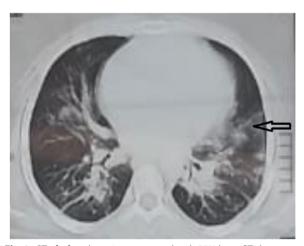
CT of a female patient presented with 25% burn CT chest show areas of the alveolar filling (black arrow)
